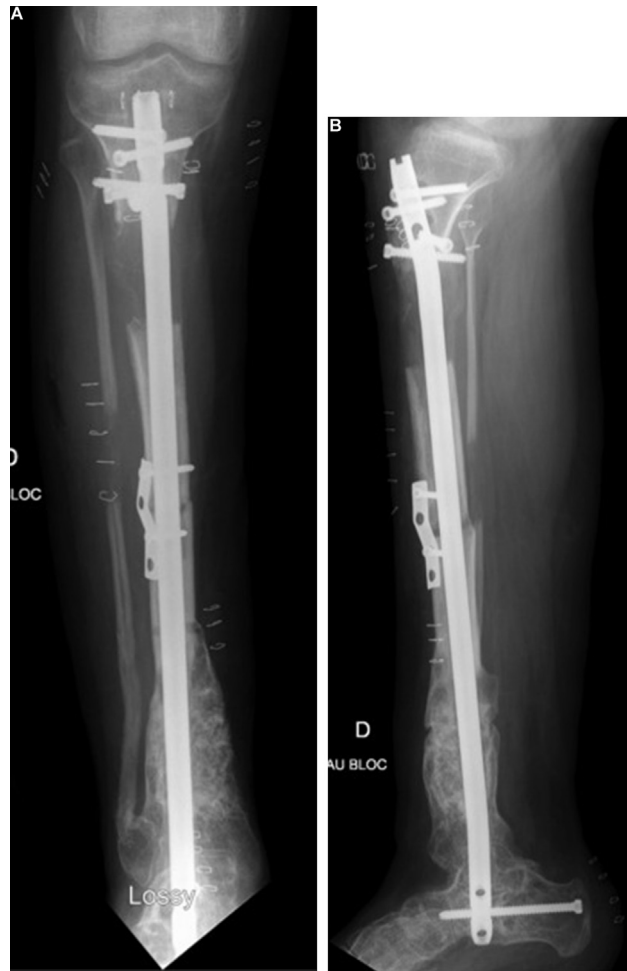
Postoperative radiographs after revision surgery for realignment using an intramedullary-locking nail; the valgus is fully corrected but the flexion deformity shows little change.
